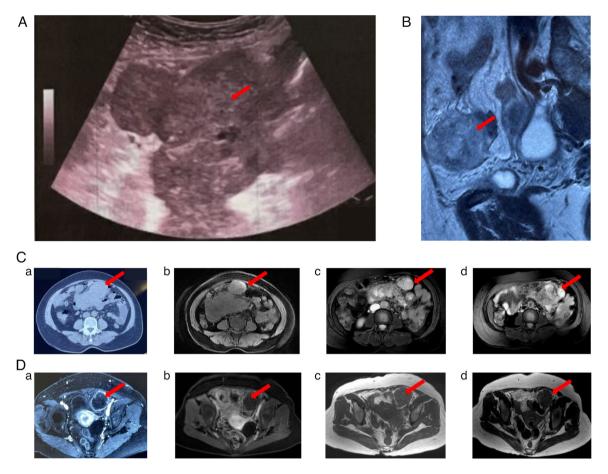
Imaging tests during diagnosis and pembrolizumab intervention. (A) Abdominal ultrasound showing multiple malignant, possibly cystic, and scattered solid areas in the double adnexal areas and mesentery of the abdominal and pelvic cavities (maximum, 11.8x7.9 cm). (B) Pelvic MRI showing oval mass and numerous partially fused nodules in abdominal and pelvic cavity. (C) Imaging examination showing the lesions in the upper abdominal cavity (maximum diameter:  $10.4x7.1 \rightarrow 8.7x6.1 \rightarrow 8.5x4.5 \rightarrow 10.8x5.9$  cm; Ca: CT images during diagnosis; Cb-d: MRI images after 2 cycles, 8 cycles, 12 cycles of pembrolizumab intervention), with obvious liquefaction necrosis in the center of those lesions. (D) MRI showing the shrunken pelvic lesions (6.5x3.1  $\rightarrow$  4.9x3.0  $\rightarrow$  3.3x2.9  $\rightarrow$  2.7x2.2 cm; Da-d: images before and after 3 cycles, 11 cycles, 13 cycles of pembrolizumab intervention). The lesion is diffuse and not solitary. To check the efficacy conveniently, the largest lesion was marked as the targeted part with red arrows.
